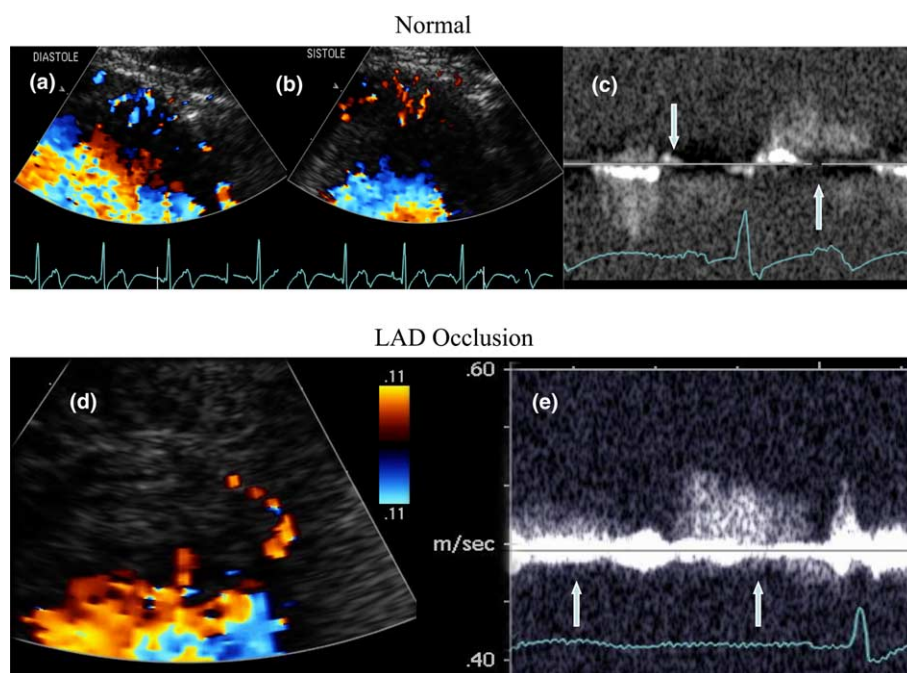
Transthoracic coronary Doppler ultrasound is a unique technique to image perforators. In normal subjects, perforators have a diastolic forward flow (panel a, coded in blue) and a systolic retrograde flow (panel b, coded in red), which is confirmed by pulsed Doppler ultrasound (panel c, arrows). In patients with coronary occlusion color Doppler ultrasound may show a characteristic flow inversion in diastole (panel d, coded in red), which is confirmed by pulsed Doppler ultrasound (panel e, arrows).
